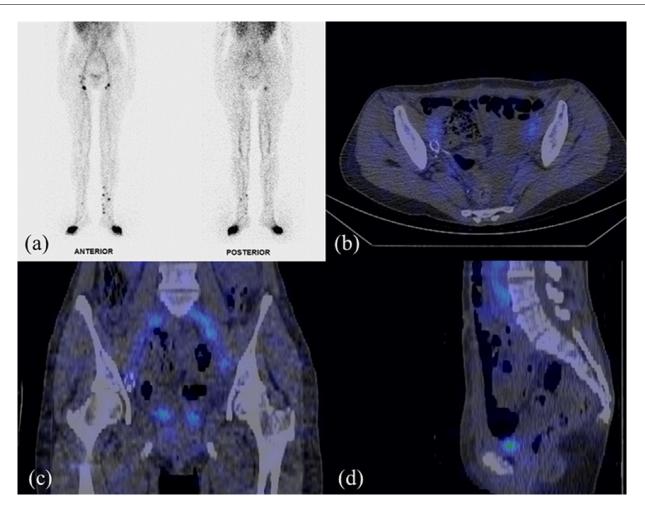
Planar image of lymphoscintigraphy and multiplanar reconstruction of SPECT/CT. (A) Six months after intranodal lymphangiography shows no abnormal extranodal isotope distribution in the pelvis. Fusion axial (B), coronal (C) and sagittal (D) SPECT/CT images of the pelvis also demonstrate no extranodal isotope distribution in the pelvic cavity. SPECT/CT: Single-photon emission computerized tomography/computed tomography.
